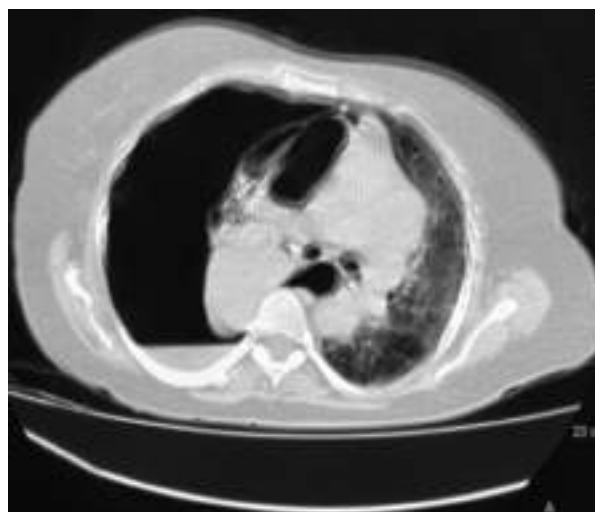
Right pneumothorax on a chest CT
